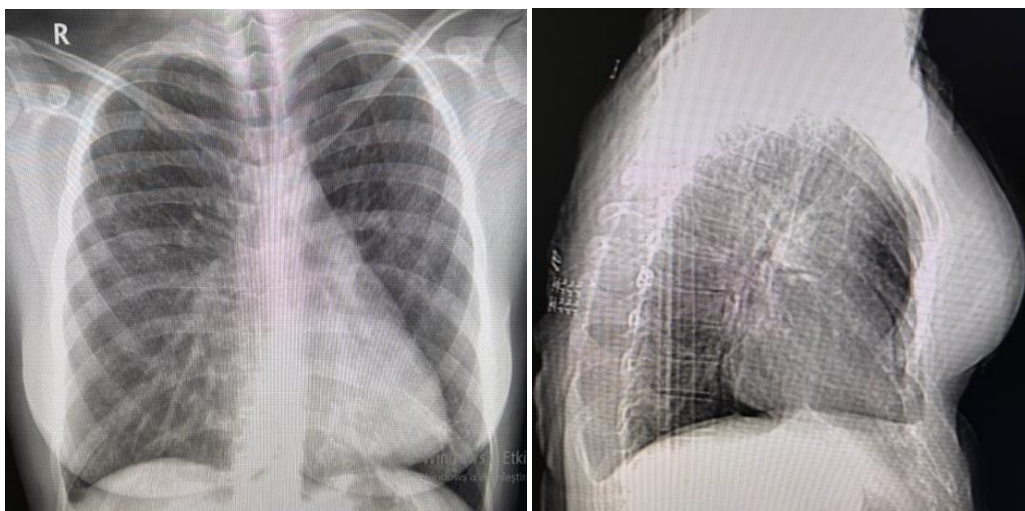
PA and left lateral chest x-ray showing pectus excavatum and scoliosis.
